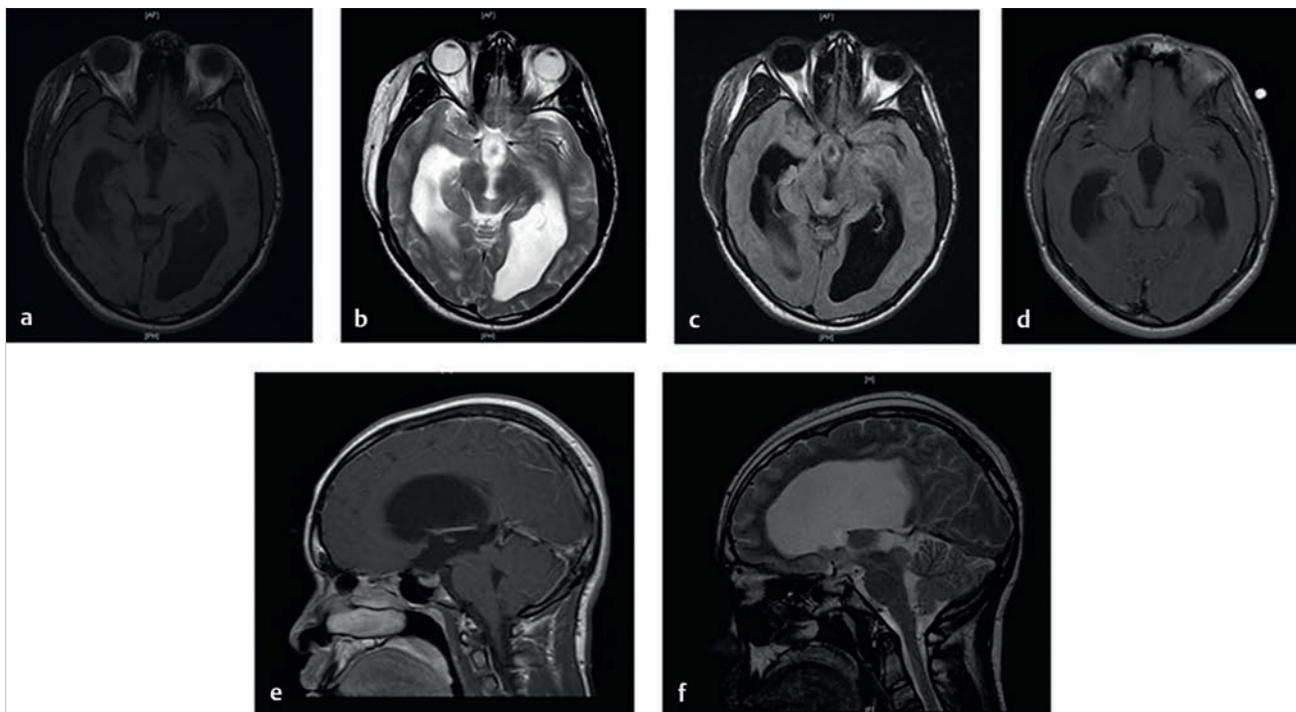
Tectal mass. (a) Axial T1-weighted magnetic resonance (MR) image of a child with a tectal mass. Note significant resulting hydrocephalus. (b) Axial T2-weighted MR image and (c) axial FLAIR (fluid-attenuated inversion recovery) MR image for the same patient demonstrating hyperintensity. (d) Axial T1-weighted MR image with gadolinium contrast demonstrating typical lack of contrast enhancement. (e) Sagittal T1-weighted MR image with gadolinium contrast and (f) sagittal T2-weighted MR image.
